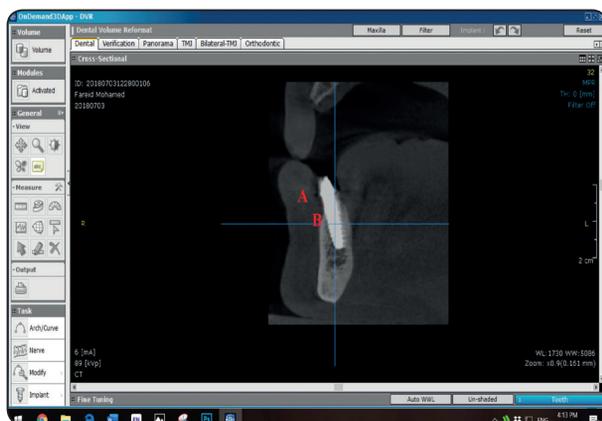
Bone height measurement using CT cross sectional images
